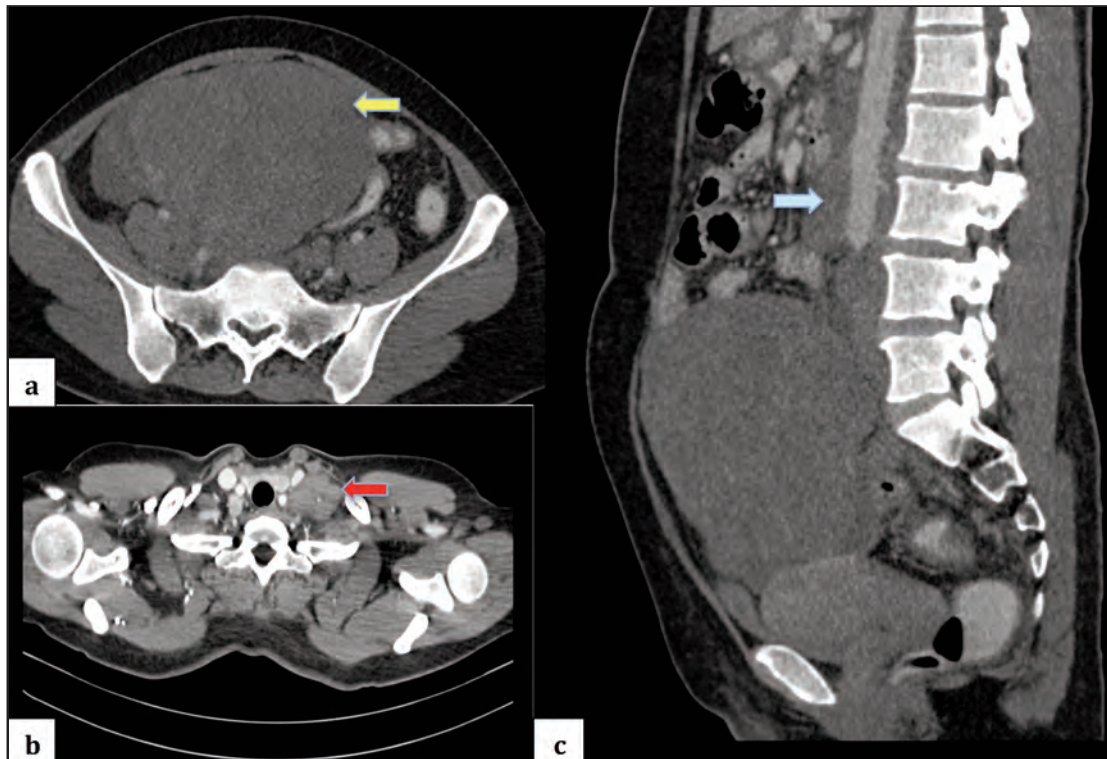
Computed tomography (CT) imaging
